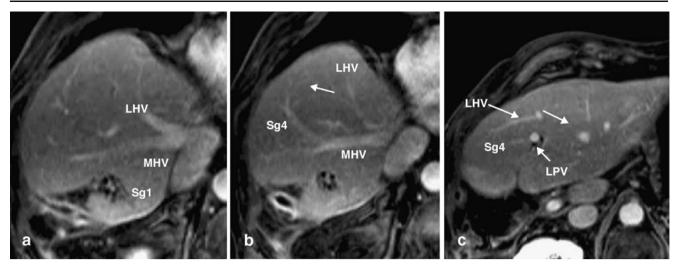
Three images from a magnetic resonance imaging (MRI) examination performed prior to cholecystectomy demonstrating position of hepatic veins. A is the most superior and C the most inferior image selected. Note tissue posterior to middle hepatic vein
